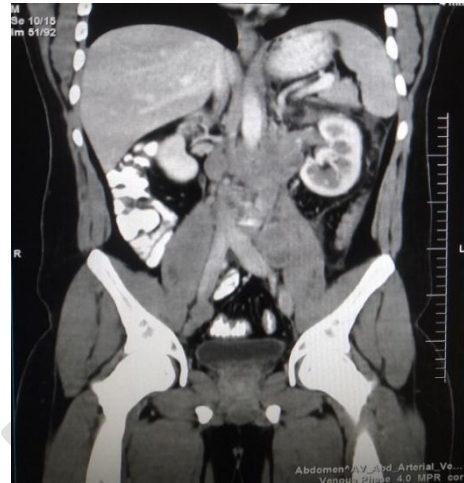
8 Coronal Image of CT scan abdomen
